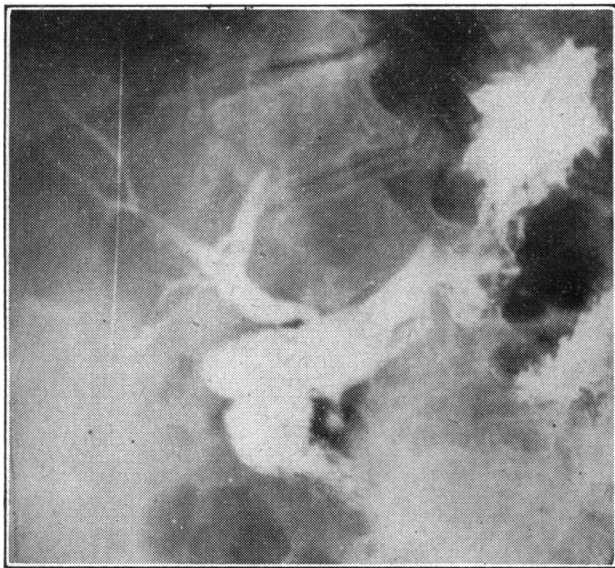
Case A. Radiograph following a barium meal 11 years after choledochoduodenostomy. Barium is clearly seen in the common bile-duct and smaller ducts higher up.
